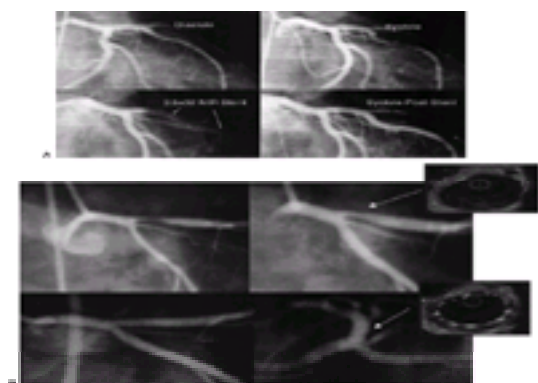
Unusual applications of stenting. A: Stenting of a severe muscle bridge. Upper panels show the left anterior descending (LAD) coronary artery in diastole and compressed in systole. Hemodynamic significance was established by thallium scintigraphy and Doppler flow wire. In the lower panels, systolic compression has been eliminated by placement of a 3.5 × 32 mm NIR stent within the bridged segment. B: Stenting as treatment for refractory coronary vasospasm. A young woman developed intermittent chest pain associated with reversible T-wave inversions in the precordial leads despite calcium blockers and nitroglycerin. Top: Angiography demonstrated a high-grade stenosis in the proximal LAD (left), which improved after intracoronary nitroglycerin administration (right). Top, inset: Intravascular ultrasound revealed moderate, eccentric soft plaque. Angiography and intravascular ultrasound after placement of a Crown stent.
